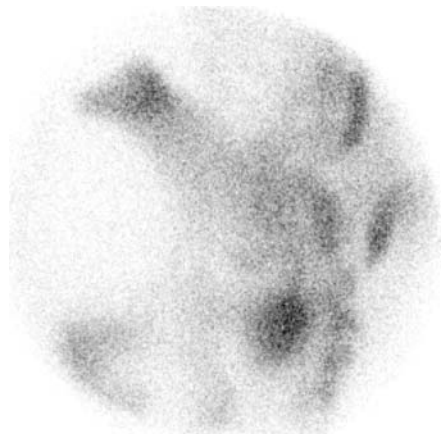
Lateral oblique scintigram of the left hemi-pelvis, with marked uptake in bladder adjacent to sacrum.
